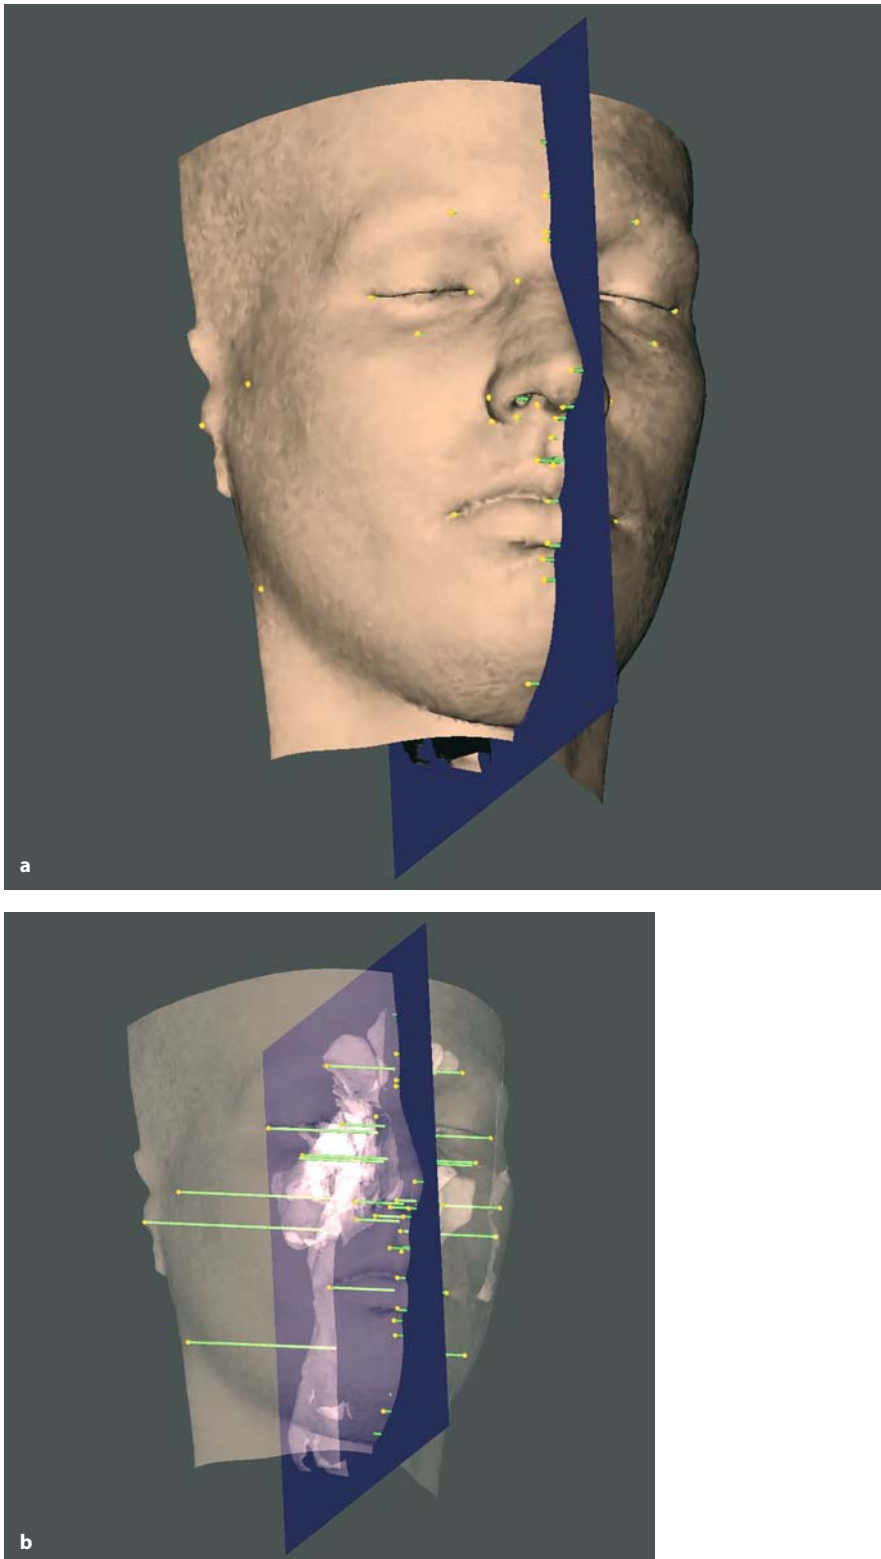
a Set-up of transverse orthogonal soft tissue measurements to the z-plane (3-D CT, patient K.C.). b Set-up of transverse orthogonal soft tissue measurements to the z-plane (3-D CT, transparent soft tissues, patient K.C.)
